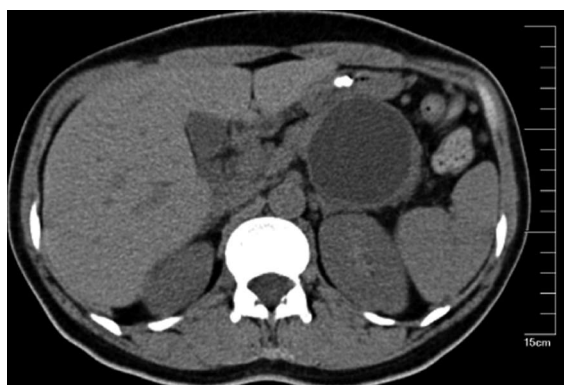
Abdominal contrast computed tomography scan of the lesion.
